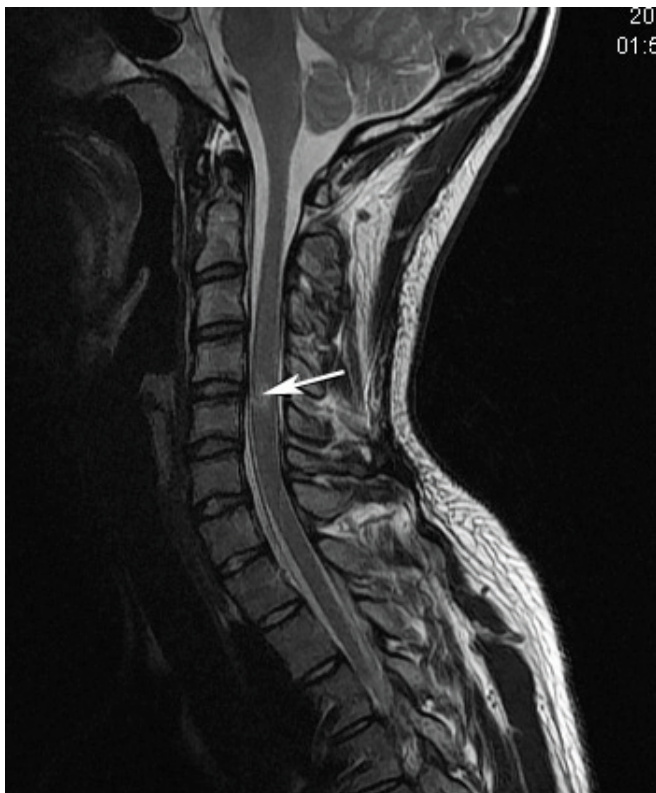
Sagittal T2-weighted MRI of cervical spine demonstrates spinal cord hyperintensity at C4 and C5 levels.
